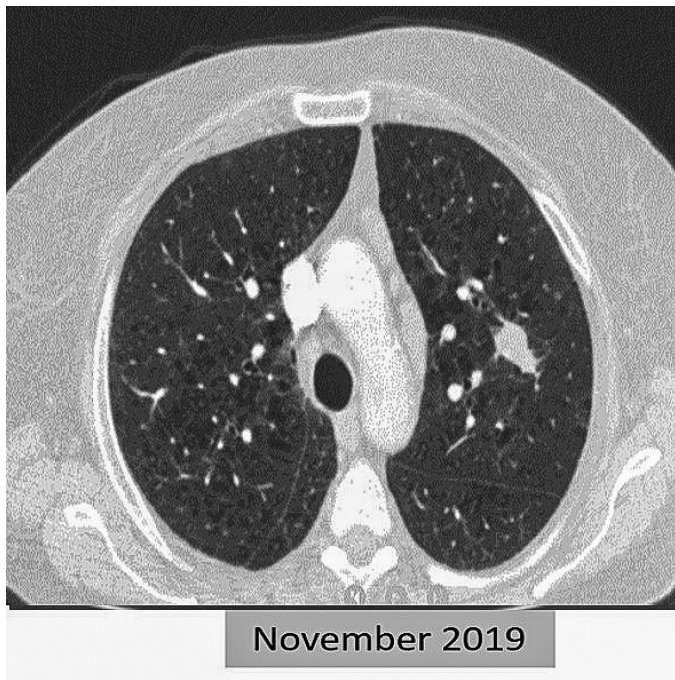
Thorax computed tomography images and first thorax computed tomography image.
